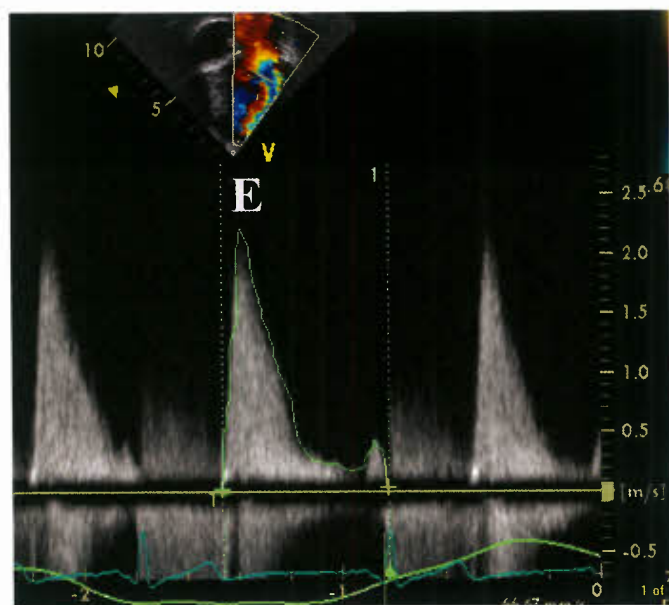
This figure demonstrates the E wave dominance of mitral inflow Doppler in a case with significant mitral valve regurgitation and no associated stenosis.
